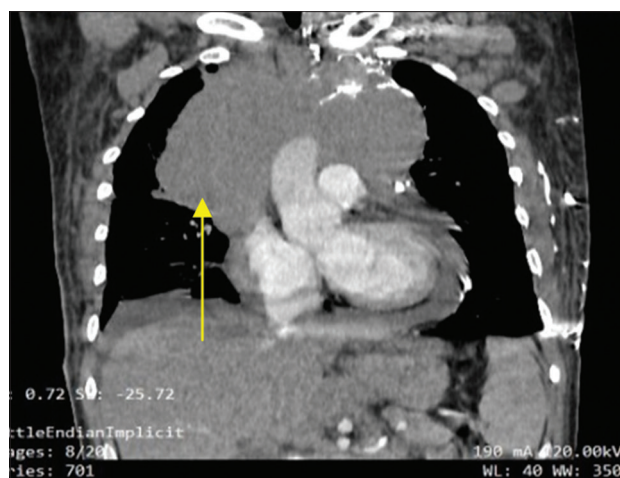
CECT study confirmed tissue mass in the mediastinum. CECT: Contrast-enhanced computed tomography
